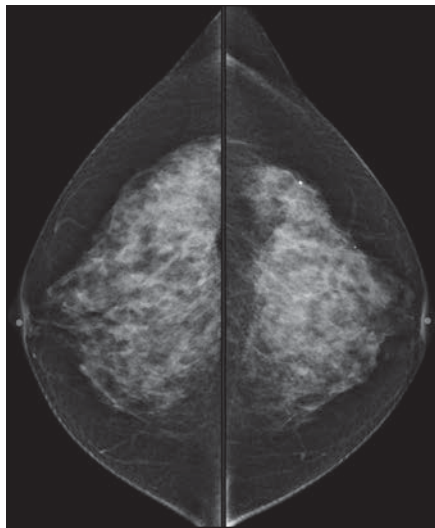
48-year-old woman with mammographically occult cancer seen on ultrasound.
